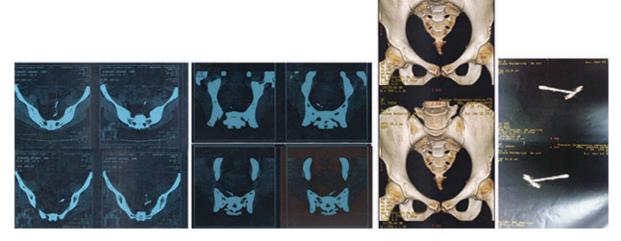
CT scan findings Showing IUCD in the Pelvis (displaced Site)
